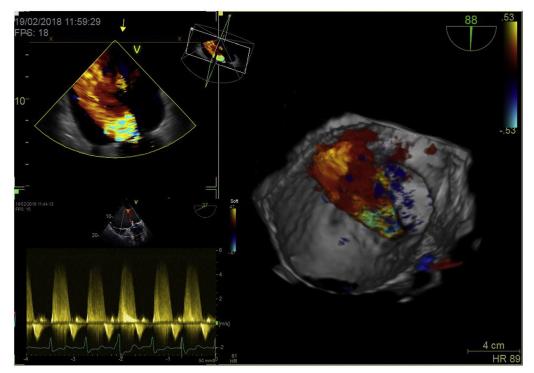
Three-dimensional transesophageal echocardiography, from an atrial view, showing a severe MV regurgitation, with a central regurgitation jet that reaches the roof of the left atrium, secondary to poor leaflet coaptation (effective regurgitant orifice area 0.45 cm², regurgitant volume 71 ml).
